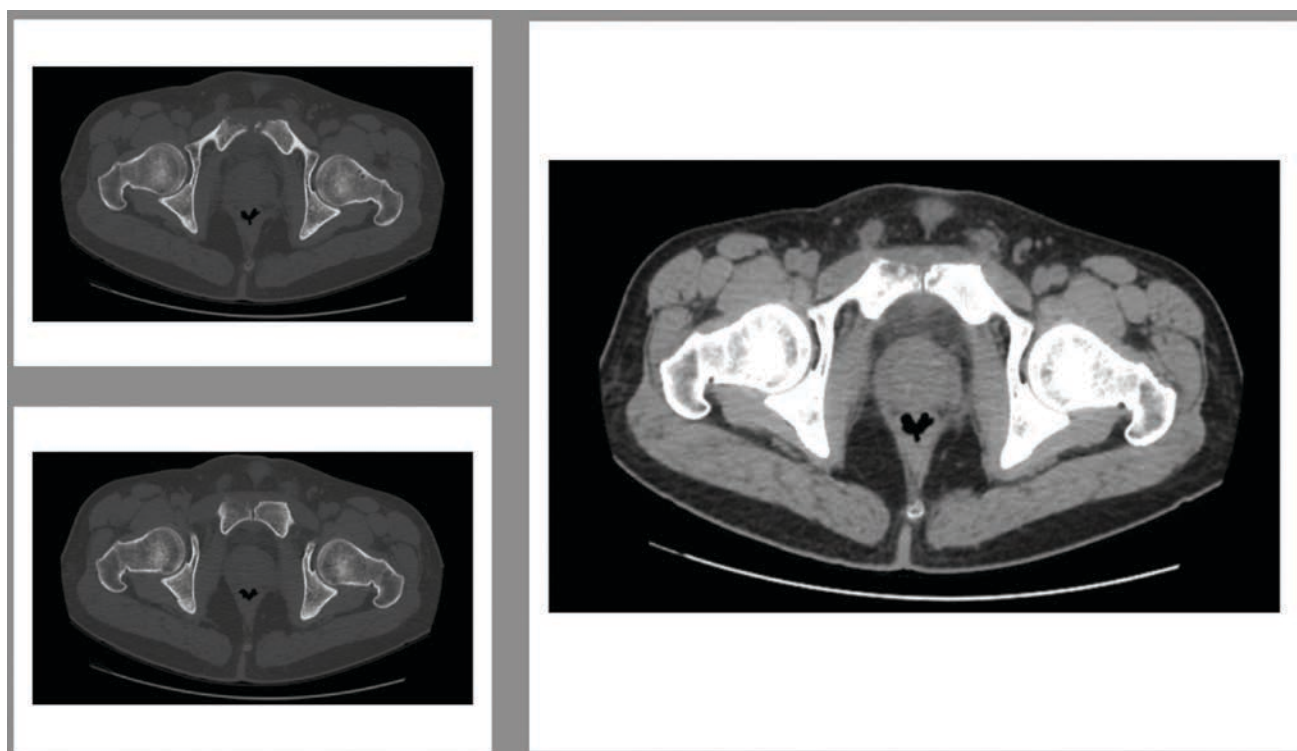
CT scan showing erosions of the right pubic bone
